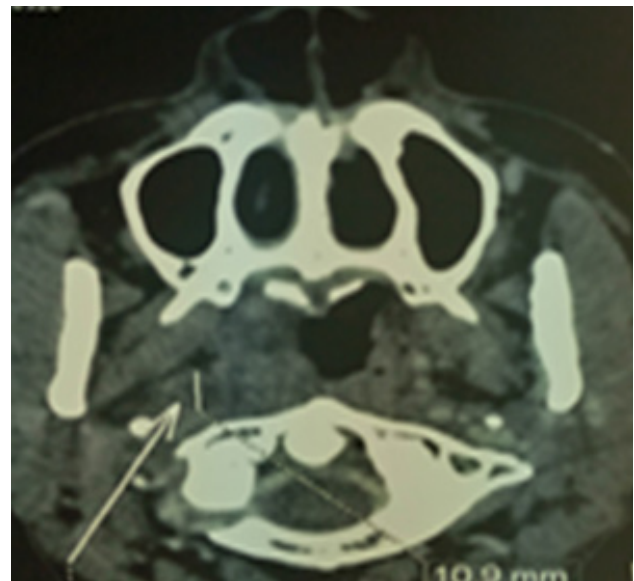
Axial CT scan image showing soft tissue mass of the right lateral pharyngeal wall with cervical lymph node (Arrow).
